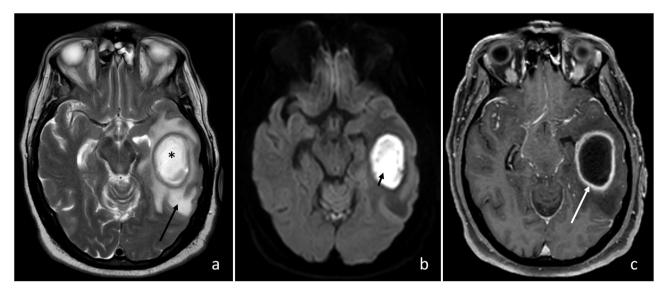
Axial MRI of the brain indicative of cerebral abscess. (a) T2-weighted image shows a large T2 hyperintense lesion (asterisk) with surrounding edema (black arrow). (b) Diffusion weighted image shows marked restricted diffusion centrally within the lesion (black arrow). (c) T1-weighted post-contrast image shows a thin rim of peripheral enhancement (white arrow).
